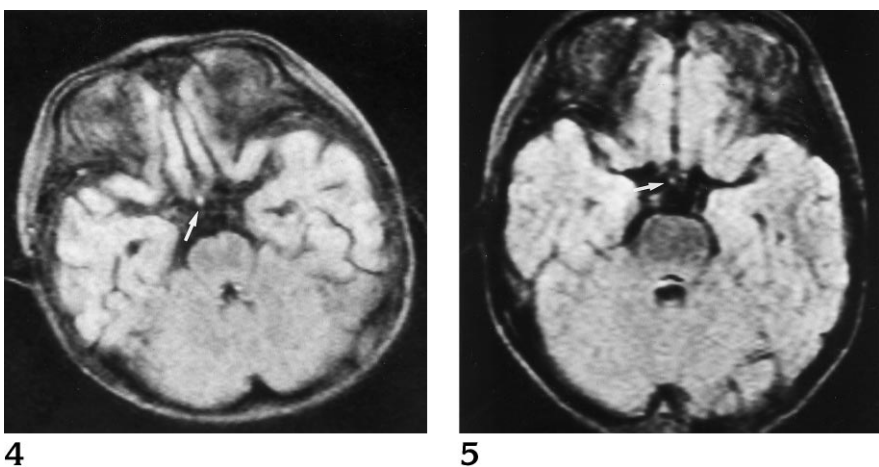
A 10-month-old infant. FLAIR MR image (obtained on a 0.5-T unit) shows the pituitary stalk as having high signal intensity relative to white matter.
